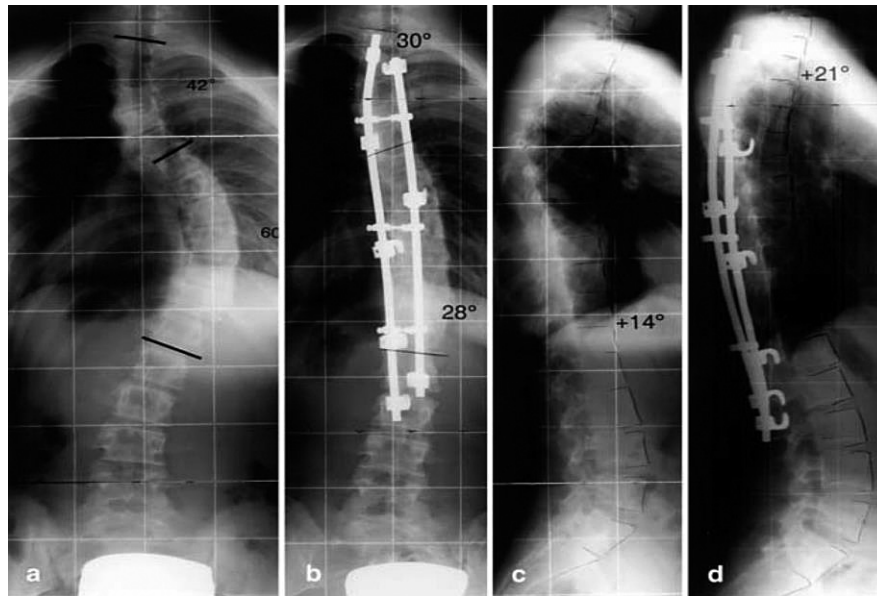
Preoperative spine X-rays of a patient with hooks instrumentation
